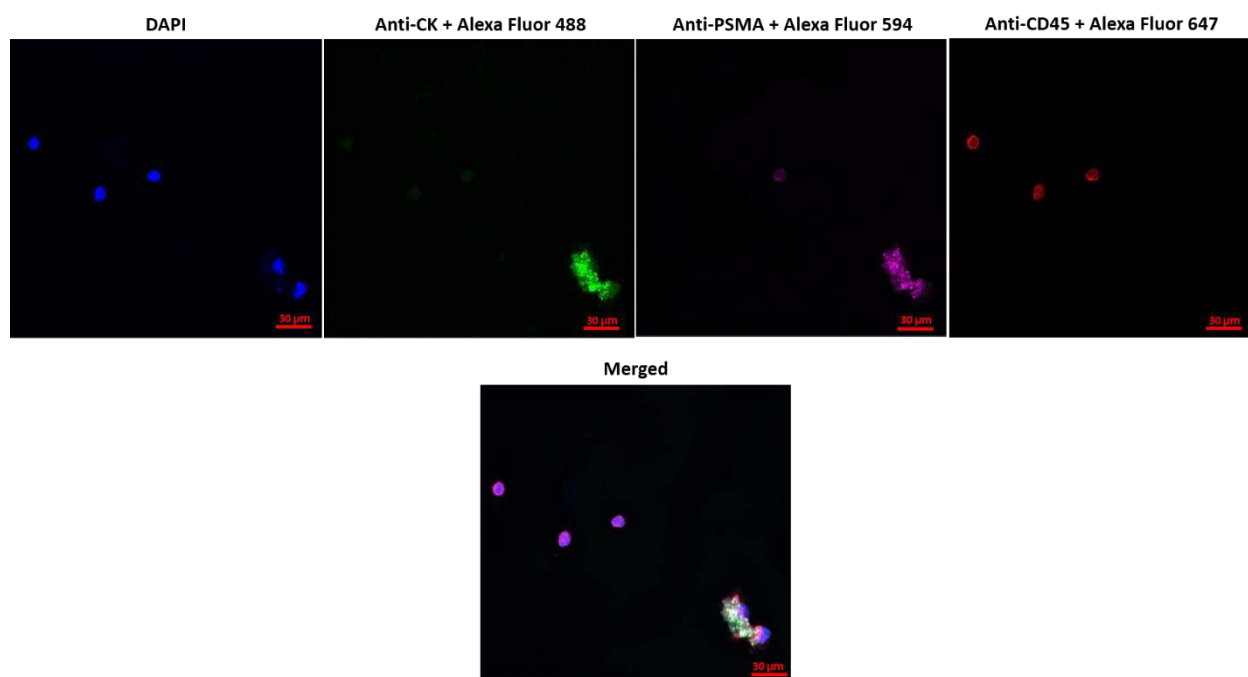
CTCs isolated from blood with the microfluidic chip and identified via immunocytochemistry. On the image, three smaller lymphocytes (CK-, PSMA-, CD45+) and two bigger CTCs (CK+, PSMA+, CD45-) can be observed.
